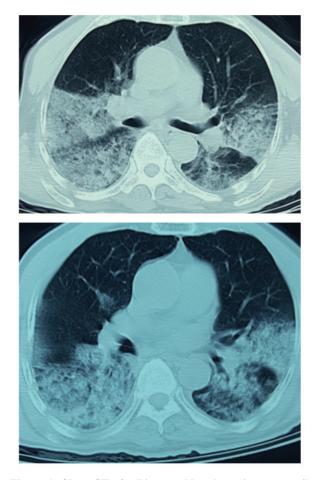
Chest CT of a 74-year-old male patient on April 5th, 2013.
